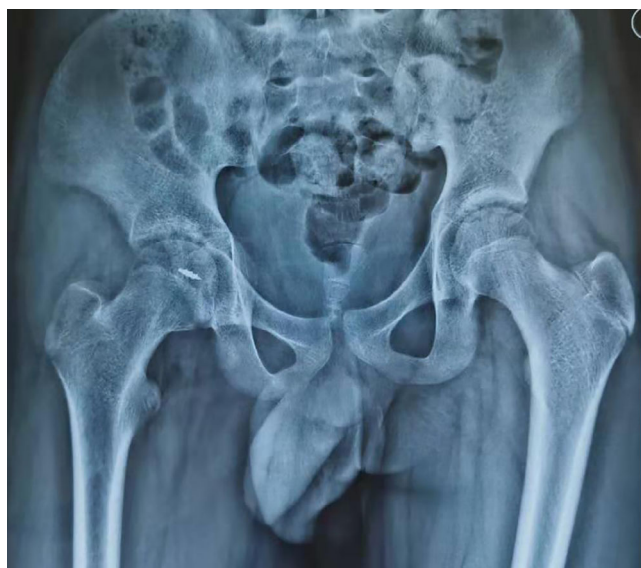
Postoperative 3 months anteroposterior X-ray of pelvis showed bone union of the acetabular posterior wall.
